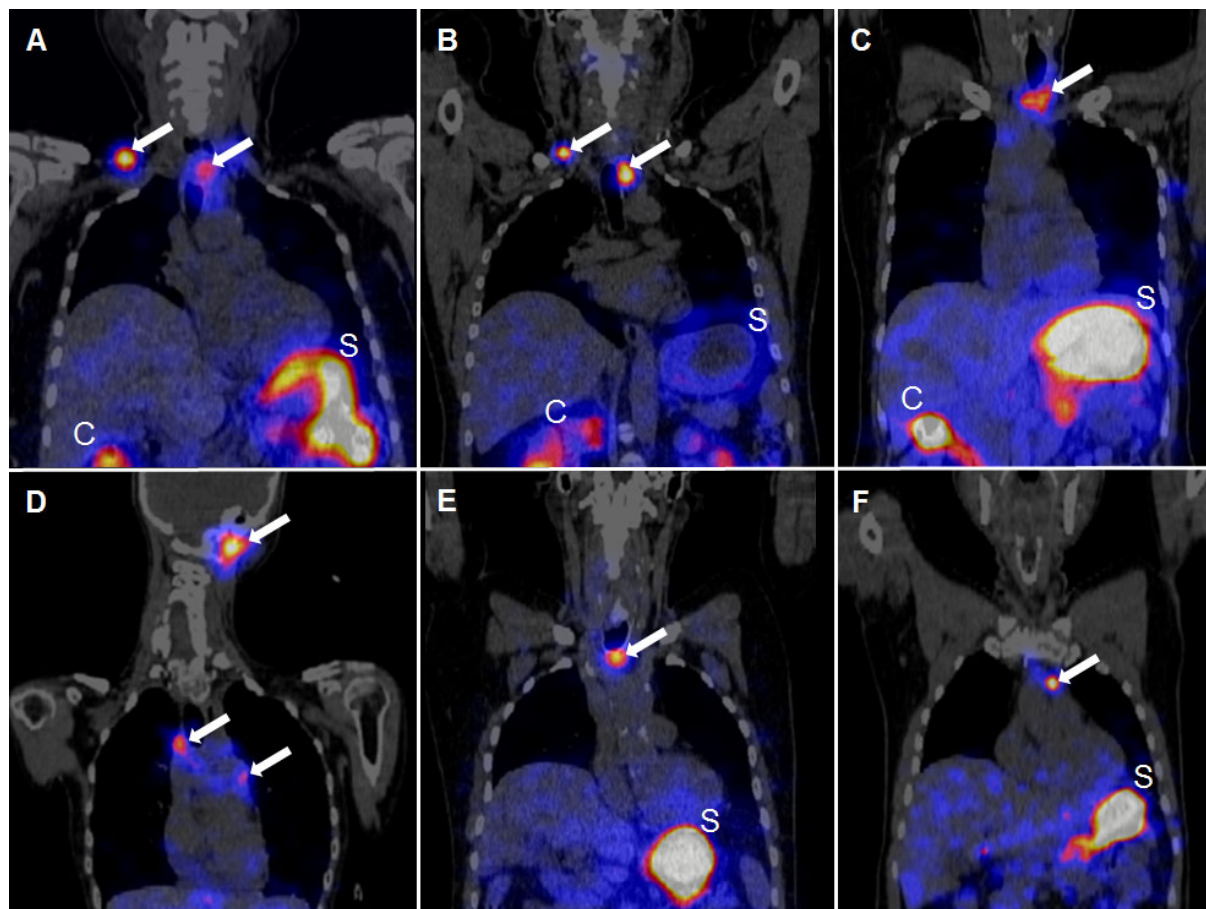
^{177}Lu -PP-F11N SPECT/CT scans 24 h p.i. in coronar orientation. In all 6 patients (A-F: patient 1-6), several tumors were visualized with SPECT (white arrows). Minimal diameter of a detectable tumor was 8 mm (F: patient 6). S = stomach, C = colon.
